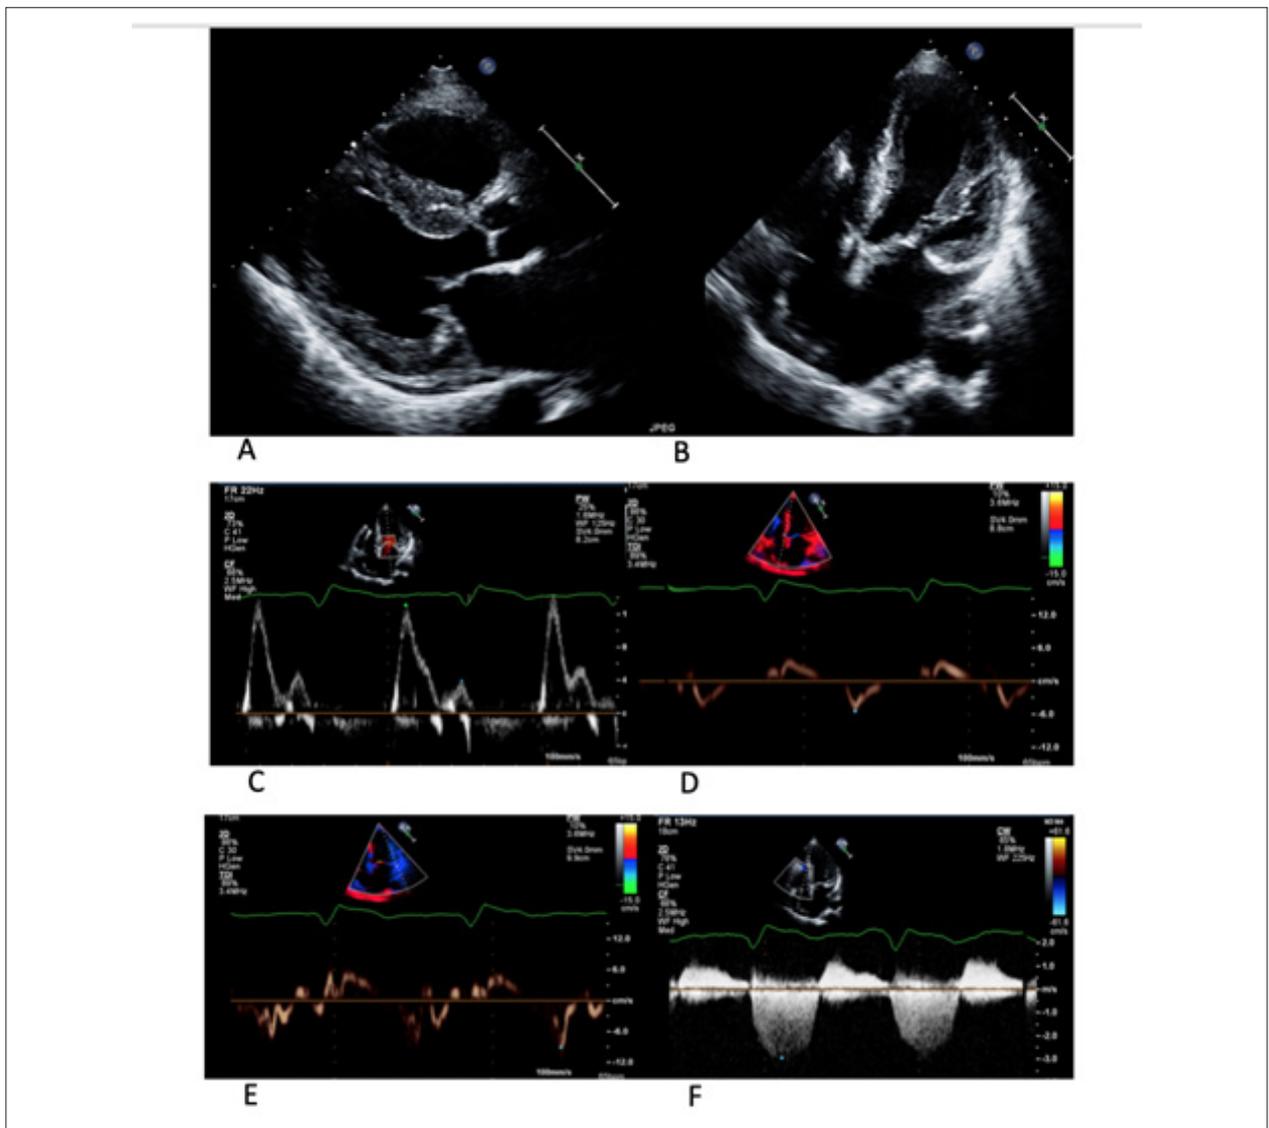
Transthoracic echocardiogram findings. Panel A (parasternal long axis view) and B (apical 4-chamber view) show increased wall thickness (maximum 15 mm in the basal interventricular septum) and mildly dilated left atrium (body-surface indexed volume of 40 mL/m²). Panel C shows increased E/A ratio of 3,4. Panel D shows a lateral e' velocity of 9 cm/s and panel E a septal e' of 5 cm/s, giving an average E/e' of 15. In panel F, tricuspid regurgitation velocity is estimated at 2,9 m/s with Cw Doppler. Therefore, the patient met the criteria for diastolic dysfunction.
